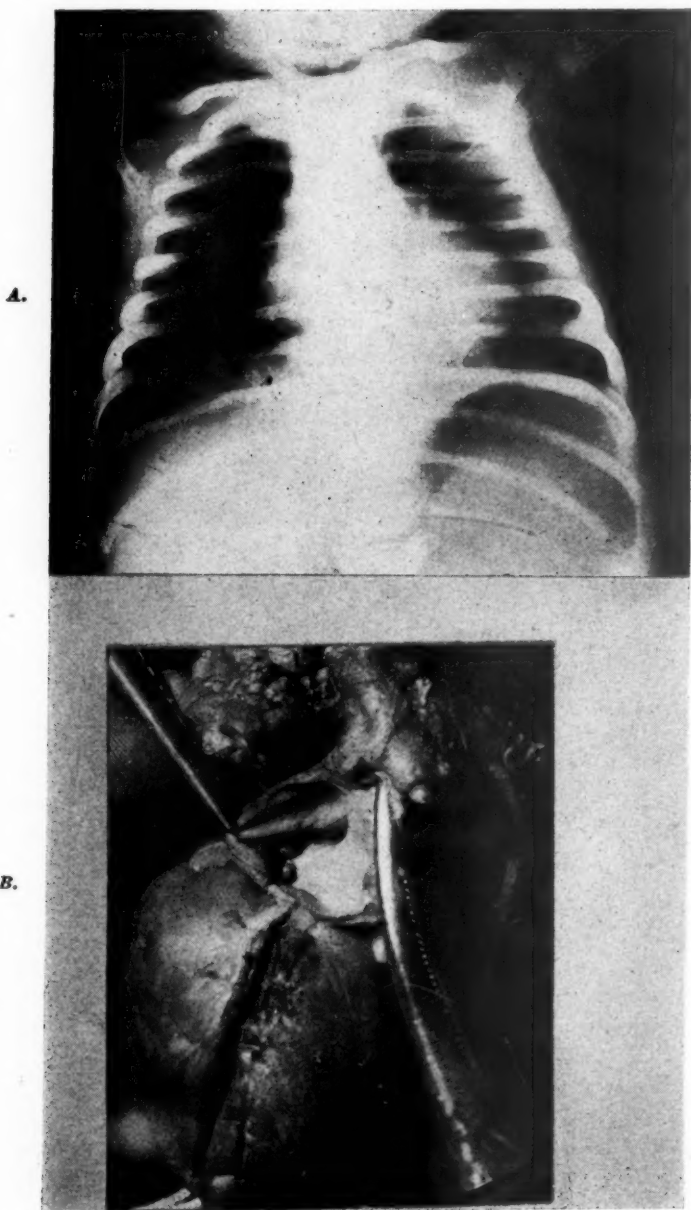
A, The roentgenogram in Case 2, taken May 7, 1943. This is not a teleroentgenogram. The heart is, however, moderately enlarged. B, The heart in Case 2, showing the prominence of the right ventricle. The thickened cusps of the pulmonary valve can be seen and the marked stenosis of the valve is apparent. The pulmonary artery, distal to the valve, is moderately dilated and the wall is delicate and thin.
